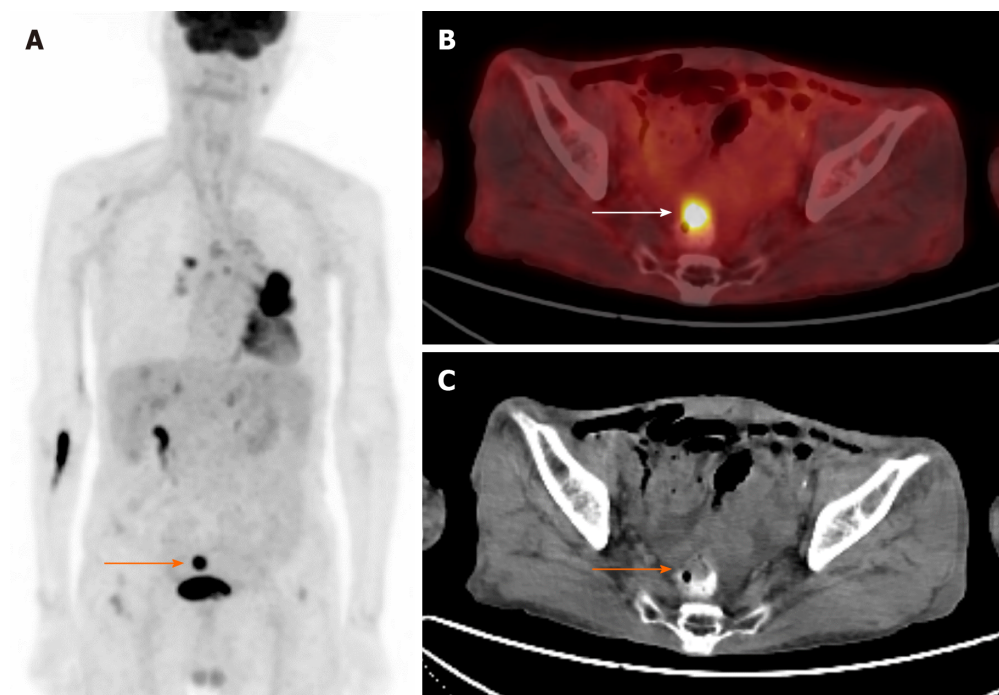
Focal intestinal fluorine-18 fluorodeoxyglucose uptake. A: Maximum intensity projection depicting focal hypermetabolism superior to the urinary bladder (arrow) in an 88-year-old man diagnosed with non-small cell lung cancer; B: Axial view revealing focal hypermetabolism localized in the rectum; C: Non-contrast-enhanced computed tomography obtained from positron emission tomography/computed tomography, highlighting a space-occupying lesion within the rectum. Notably, a discernible posterior radioopaque area suggests the presence of residual contrast material from a prior contrast-enhanced examination. Subsequent colonoscopy and pathological analysis definitively identified the lesion as adenocarcinoma originating from the rectum.
